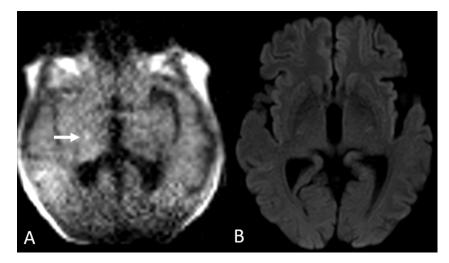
75 year old female who presented to hospital with new left-sided weakness. pMRI DWI sequence (A) showed questionable punctate focus of diffusion restriction in the right thalamocapsular region (arrow) raising the possibility for an acute infarct. Conventional stationary MRI brain several hours later showed no diffusion restriction in this area (B).
